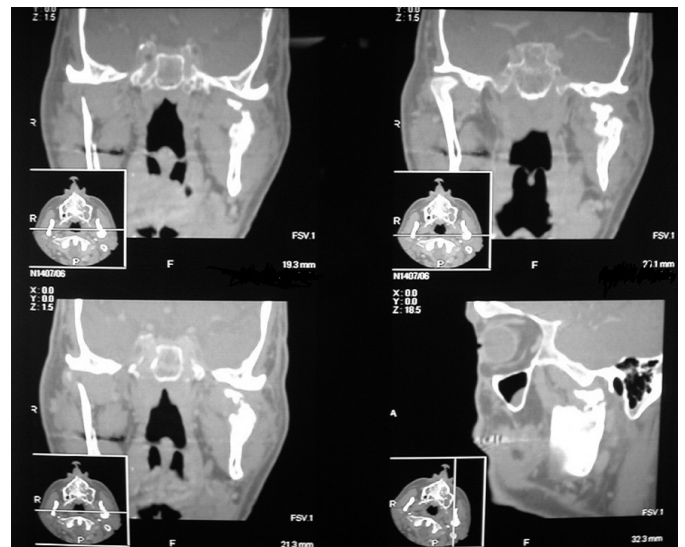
Preoperative CT revealing an osteolytic lesion with mandibular-condyle pathologic fracture.
